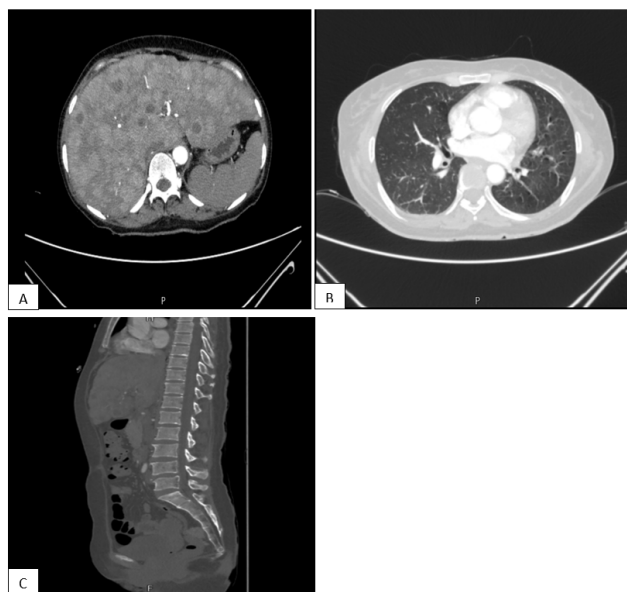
A): Baseline CT scan of abdomen showing multiple liver SOLs; B): Baseline CT of chest shows no lesion; C): Baseline CT shows no bony lesions
